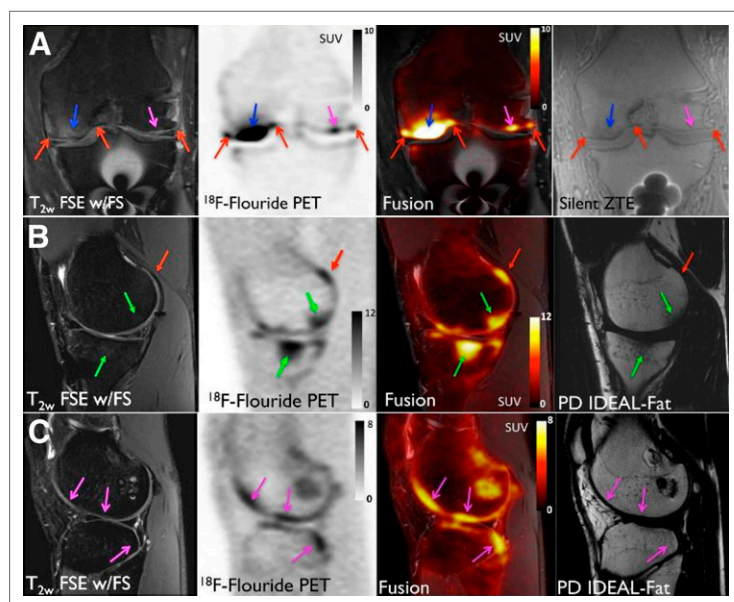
Bone marrow lesions (blue arrows), osteophytes (red arrows), and sclerosis (green arrows) findings on MR imaging were correlated with high ^{18}F -NaF uptake on PET. Several regions of high uptake on PET did not correlate with MR findings.
